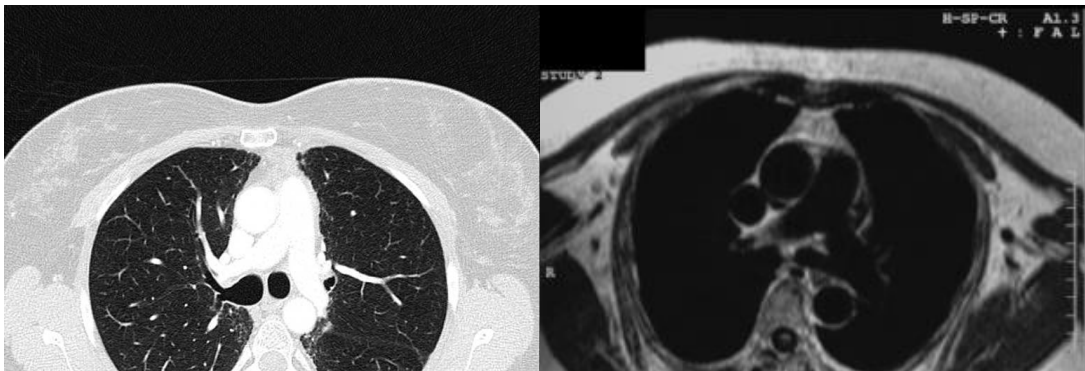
[L] Axial CT image of a human lung. The bronchi and bronchioles are noticeable features within the lung due to CT's great spatial resolution and tissue-air contrast. [R] Axial MR image of a human lung using a typical pulse sequence. No signal is produced from within the lung due to air's short transverse relaxation time (T2). Case courtesy of Dr Mohammad Taghi Niknejad, Radiopaedia.org, rID: 61444
